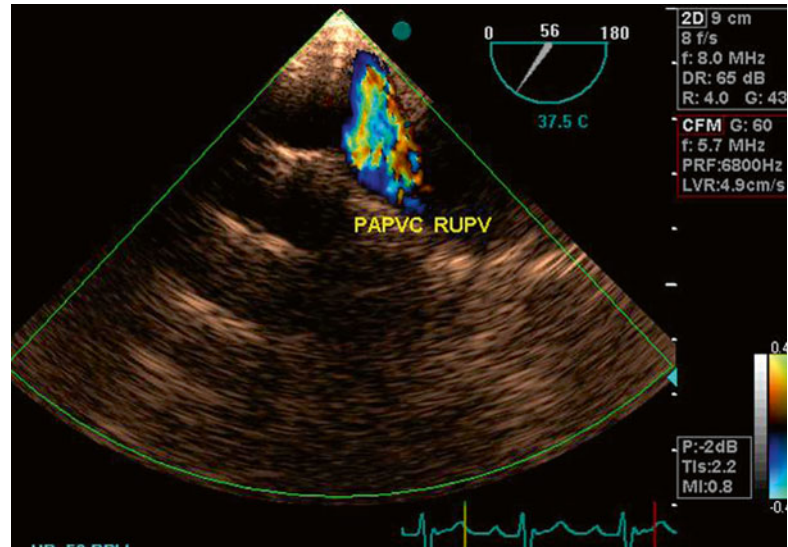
Doppler study, confirming the abnormal drainage of the right upper pulmonary vein to the right atrium
